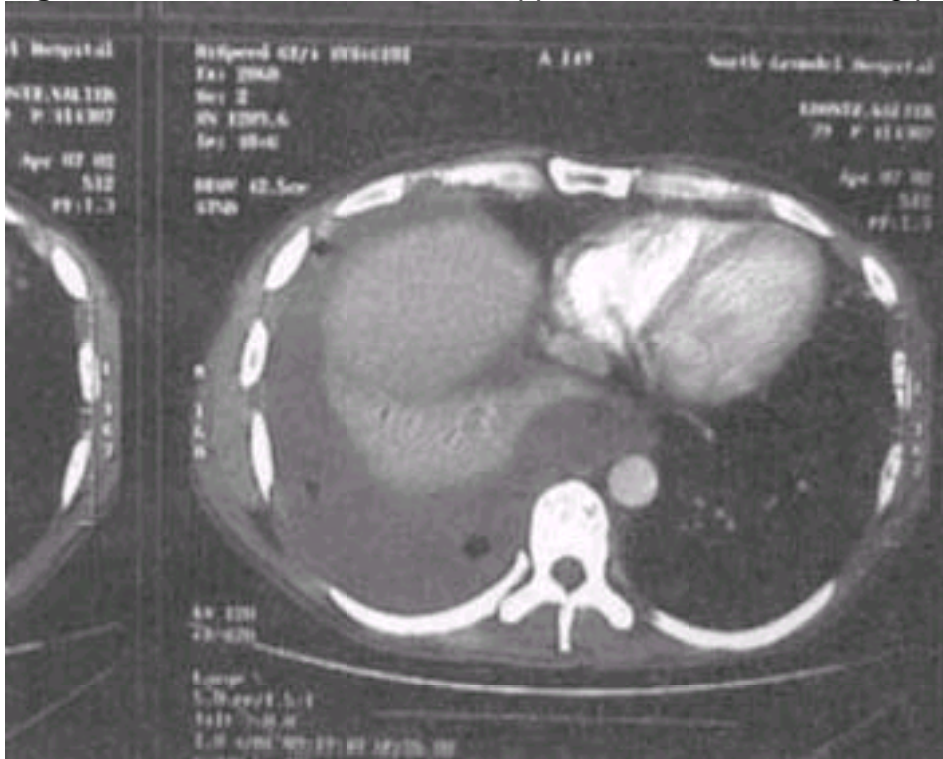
Massive pleural effusion. A repeat radiograph after thoracentesis demonstrates underlying mass.
